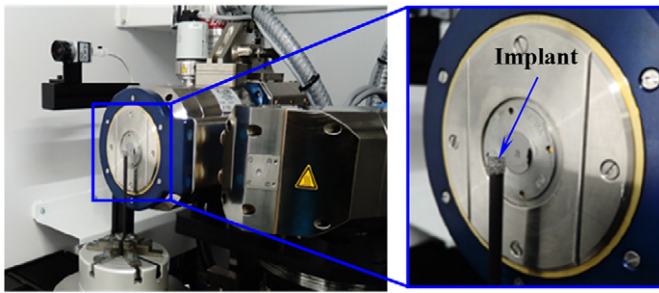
X-ray CT scanning for the implant using YXLON FF35 CT system.
